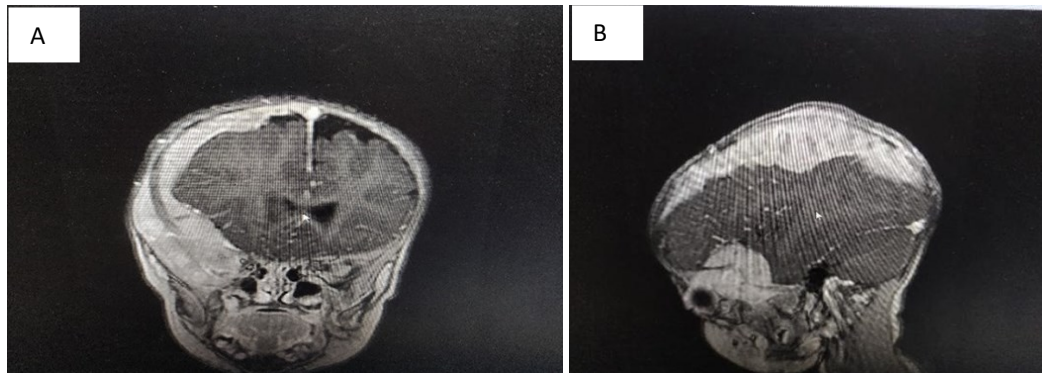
A: MRI of the skull contrasted coronal slice B: MRI contrasted sagittal slice.
